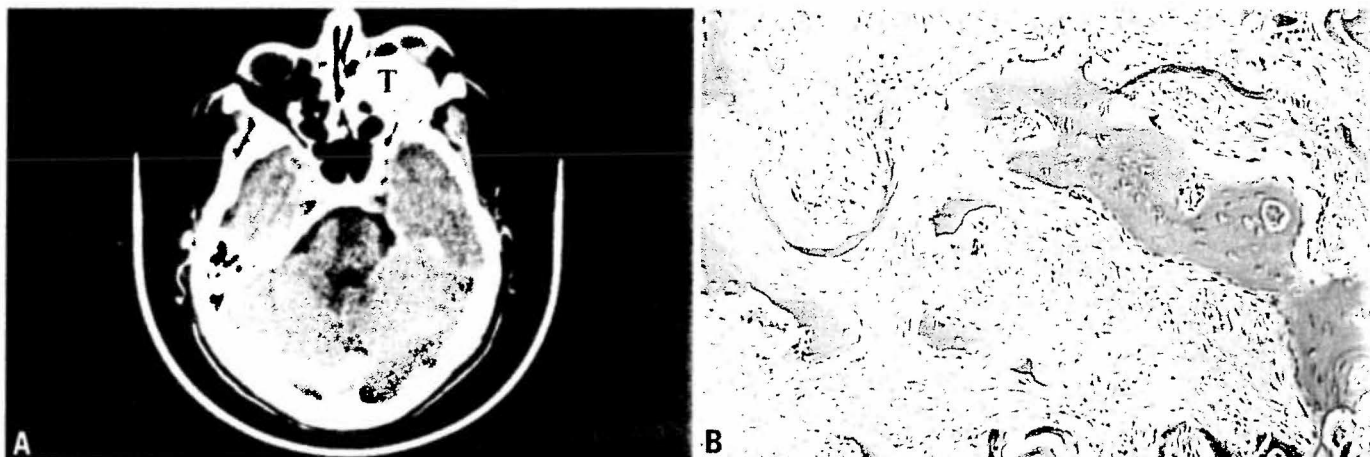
Hyperparathyroidism - jaw tumour syndrome (HPT-JT). A CT showing a well demarcated fibroosseous lesion in the maxillary antrum. B Typical jaw lesion from a patient with HPT-JT syndrome with a dense, relatively avascular fibroblast-rich stroma and irregular spicules of woven bone, some of which show at least a focal rim of osteoblasts.
